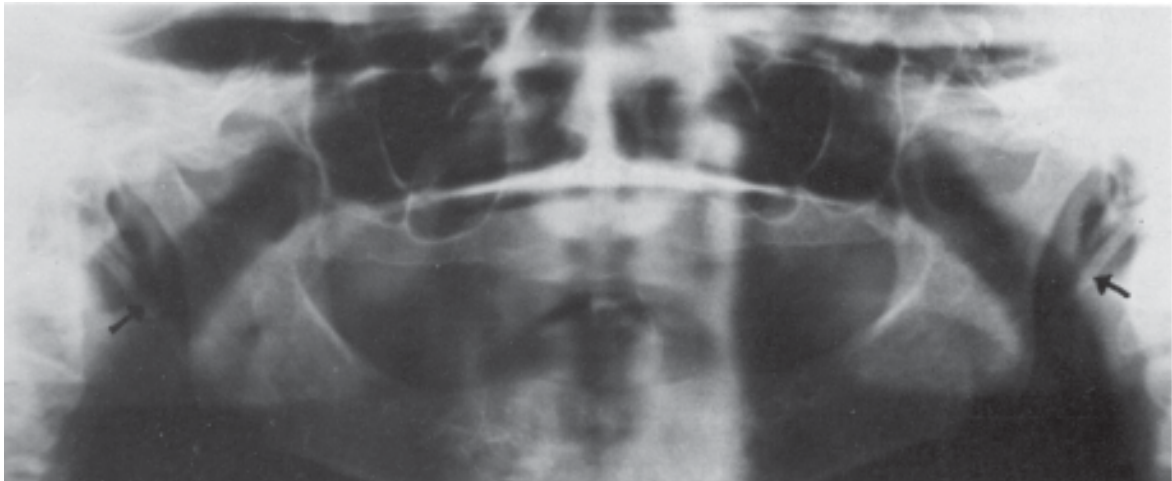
Panoramic radiograph showing bilateral elongated styloid processes.
